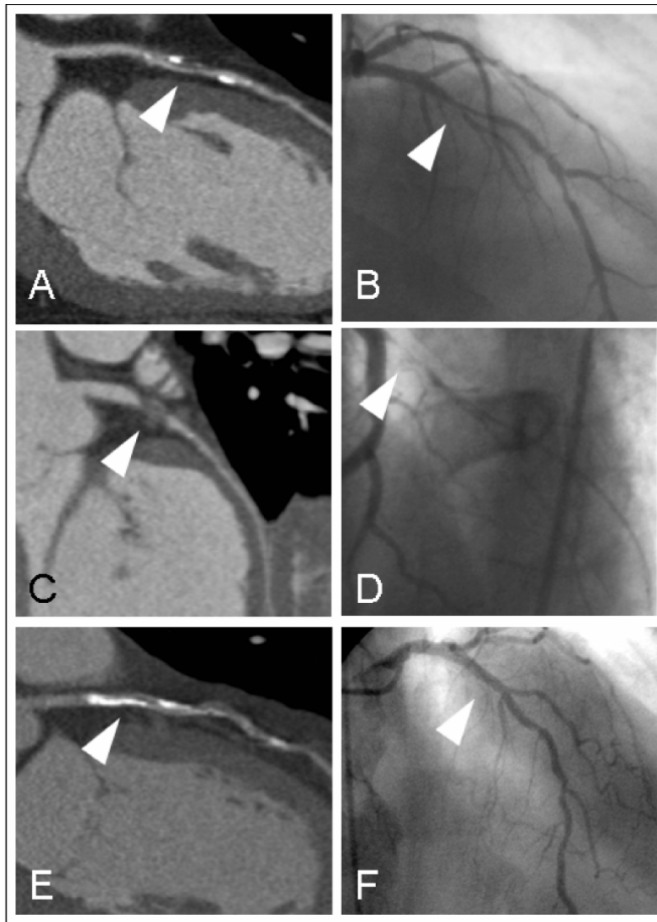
Case examples of curved multiplanar reconstruction images of computed tomography coronary angiography showing obstructive coronary artery disease (A, C, E) and invasive coronary angiography (B, D, F) images of the identical vessels. Obstructive mixed plaque in the proximal left anterior descending coronary artery (LAD), which was confirmed by invasive coronary angiography (A, B, arrowheads). Obstructive non-calcified plaque in circumflex coronary artery, which was confirmed by invasive coronary angiography (C, D, arrowheads). Obstructive calcified plaque in proximal LAD on computed tomography coronary angiography, which was not significant on invasive coronary angiography (E, F, arrowheads).
